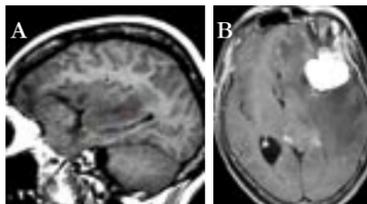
Low grade glioma. A. Sagittal noncontrast T1-weighted image shows focal mass (→) in the right frontoparietal operculum. B. Coronal FLAIR image shows expansile hyperintense mass involving the opercular cortex.
